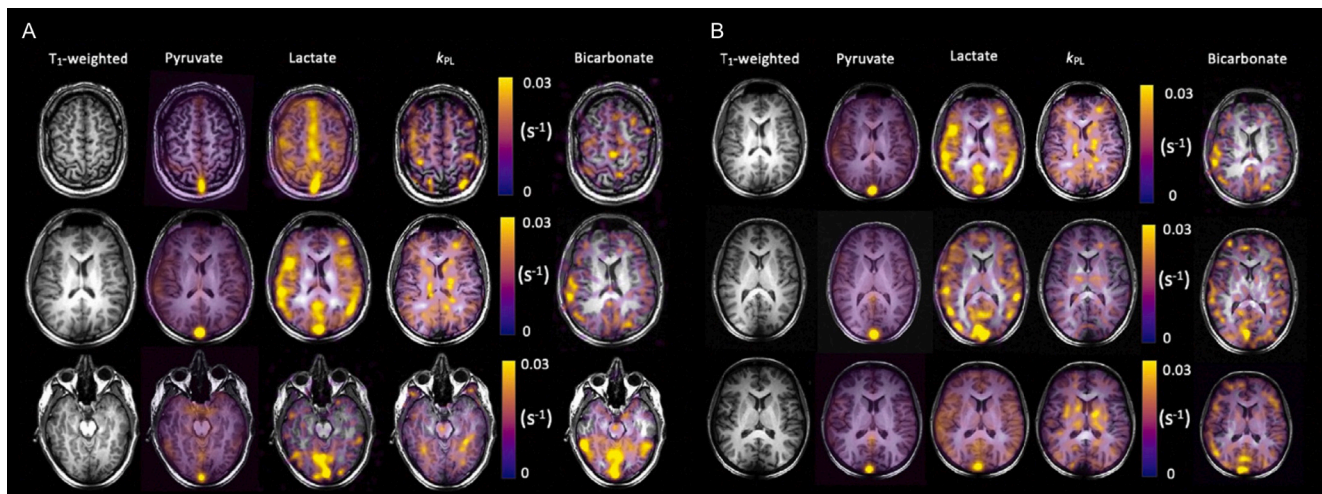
Hyperpolarized ^{13}C -MRI in two healthy volunteers (A and B) demonstrating metabolite distribution within the healthy human brain following injection of hyperpolarized ^{13}C -pyruvate. Adapted with permission from Grist *et al.* [86].
